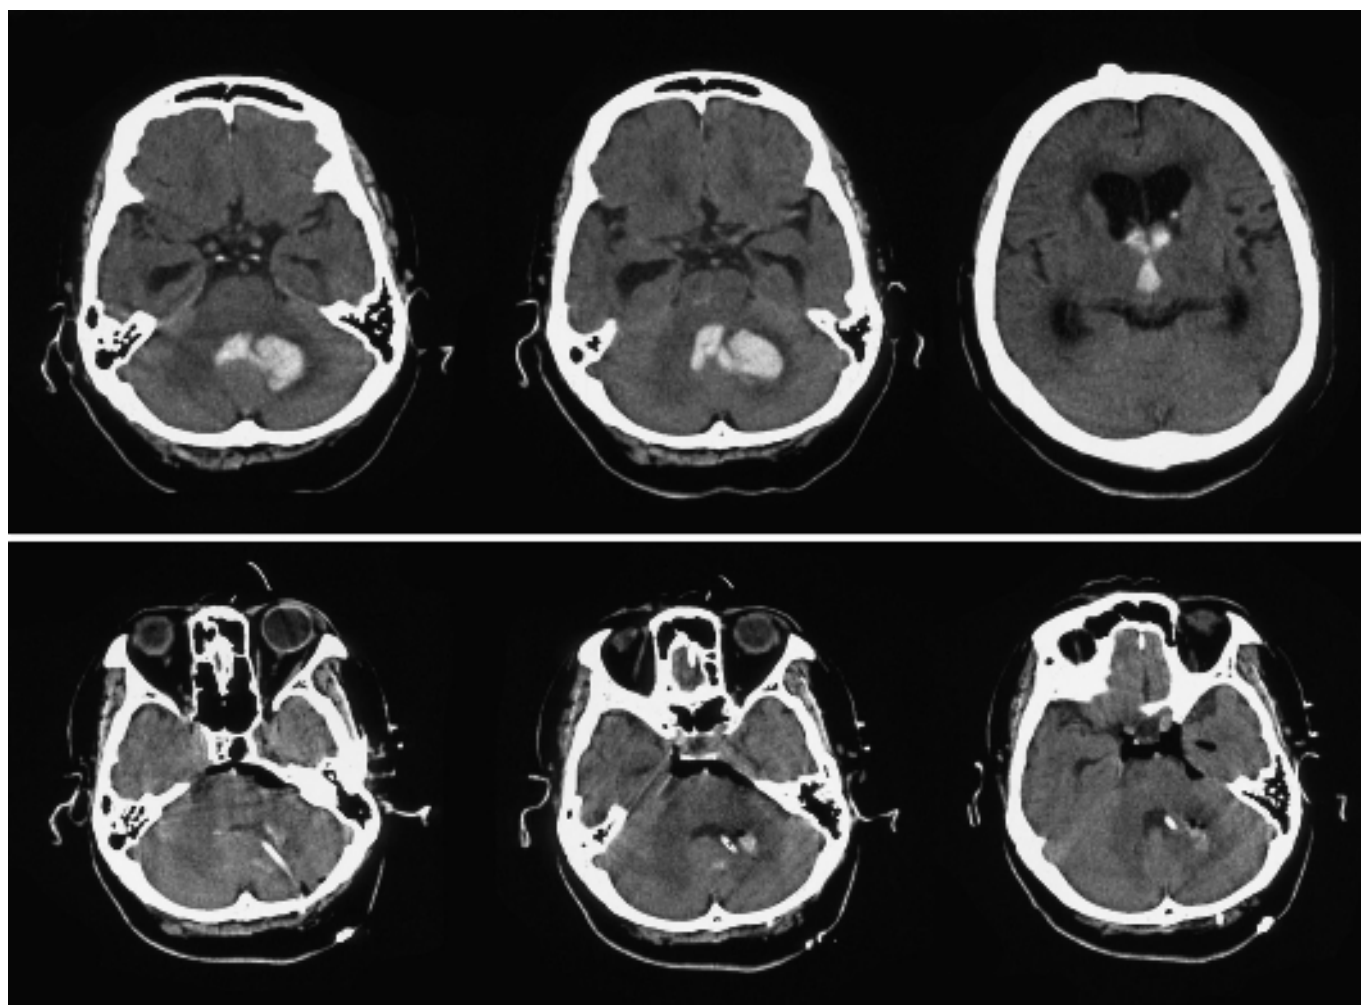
Case 1. Upper panel: Preoperative CT scans revealing left cerebellar hemorrhage with intra-fourth ventricular hematoma causing obstructive acute hydrocephalus. Lower panel: Postoperative CT scans showing removal of the hematoma in both the cerebellum and fourth ventricle.
